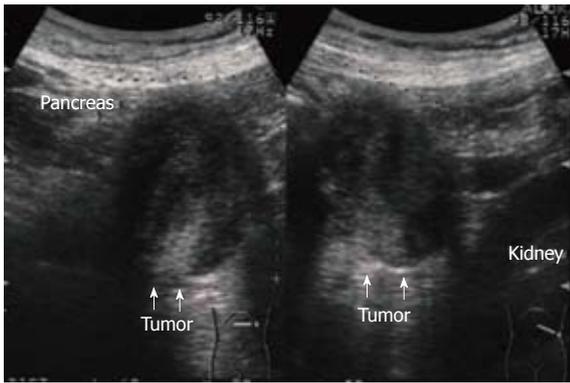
Abdominal ultrasonography showed a low-echoic mass sandwiched between the pancreas and left kidney, measuring 55 mm in its greatest diameter (arrows).
